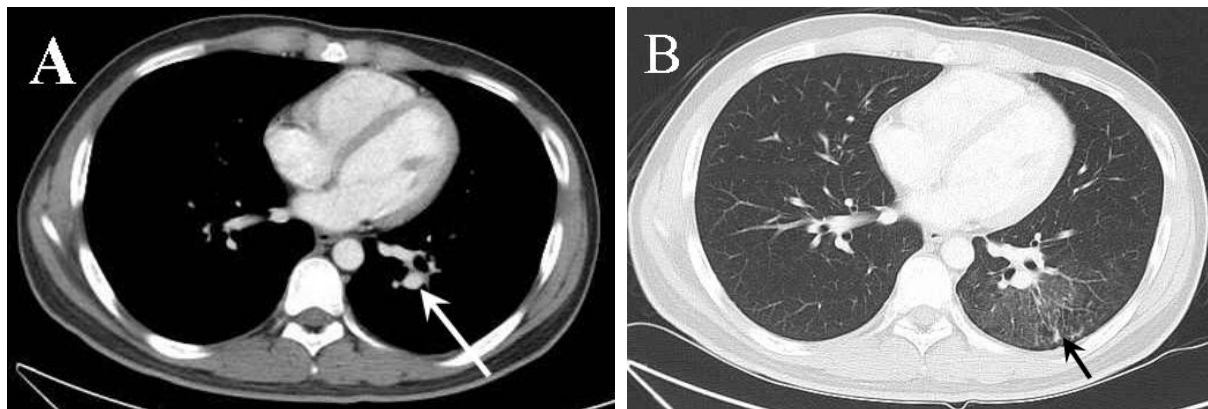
A. Contrast-enhanced CT of the chest shows a strong enhancing nodule (white arrow) in the left lower lung. B. CT of the chest at the same level as A showed mild ground-glass opacity (black arrow), consistent with retained hemorrhage.
